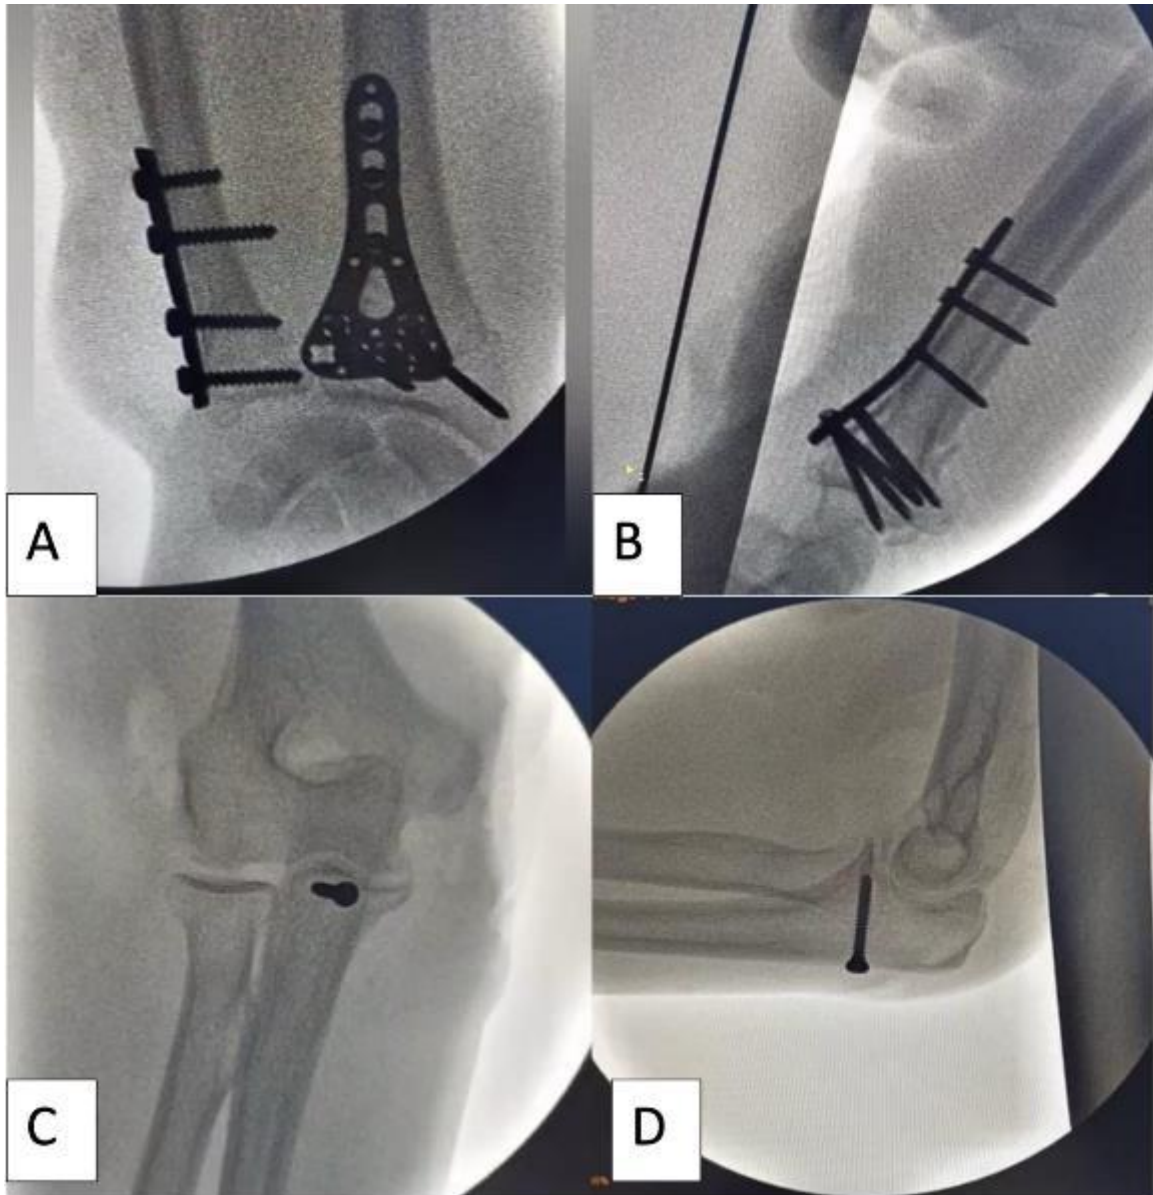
Postoperative control radiograph after osteosynthesis of the radius and ulna with plates and retrograde screw fixation(A)(B) of the coronoid process and reduction of the dislocation(C)(D)
